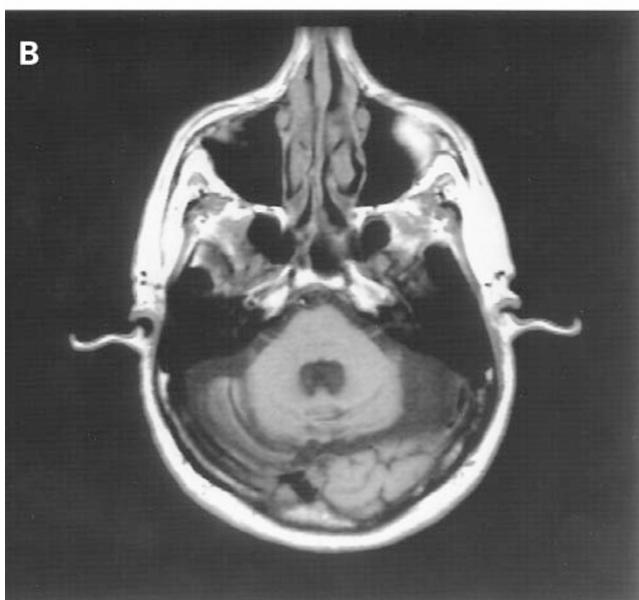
MRI of a SCA6 patient after 10 years' disease⁵³. A Inversion Recovery T2 weighted (TR 4000 ms; TE 17 ms) image on a strictly mid-sagittal section with major cerebellar atrophy and preserved brainstem and cerebrum; B Spin Echo T1 weighted (TR 640 ms; TE 11 ms) image on axial section through the pons and the cerebellum. The cerebellar vermis and cortex are severely atrophied, the pons is spared. (by permission of Dr Ayman Tourbah)
